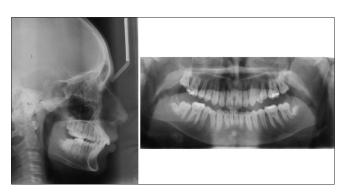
Postfunctional appliance panoramic radiograph and lateral cephalogram
